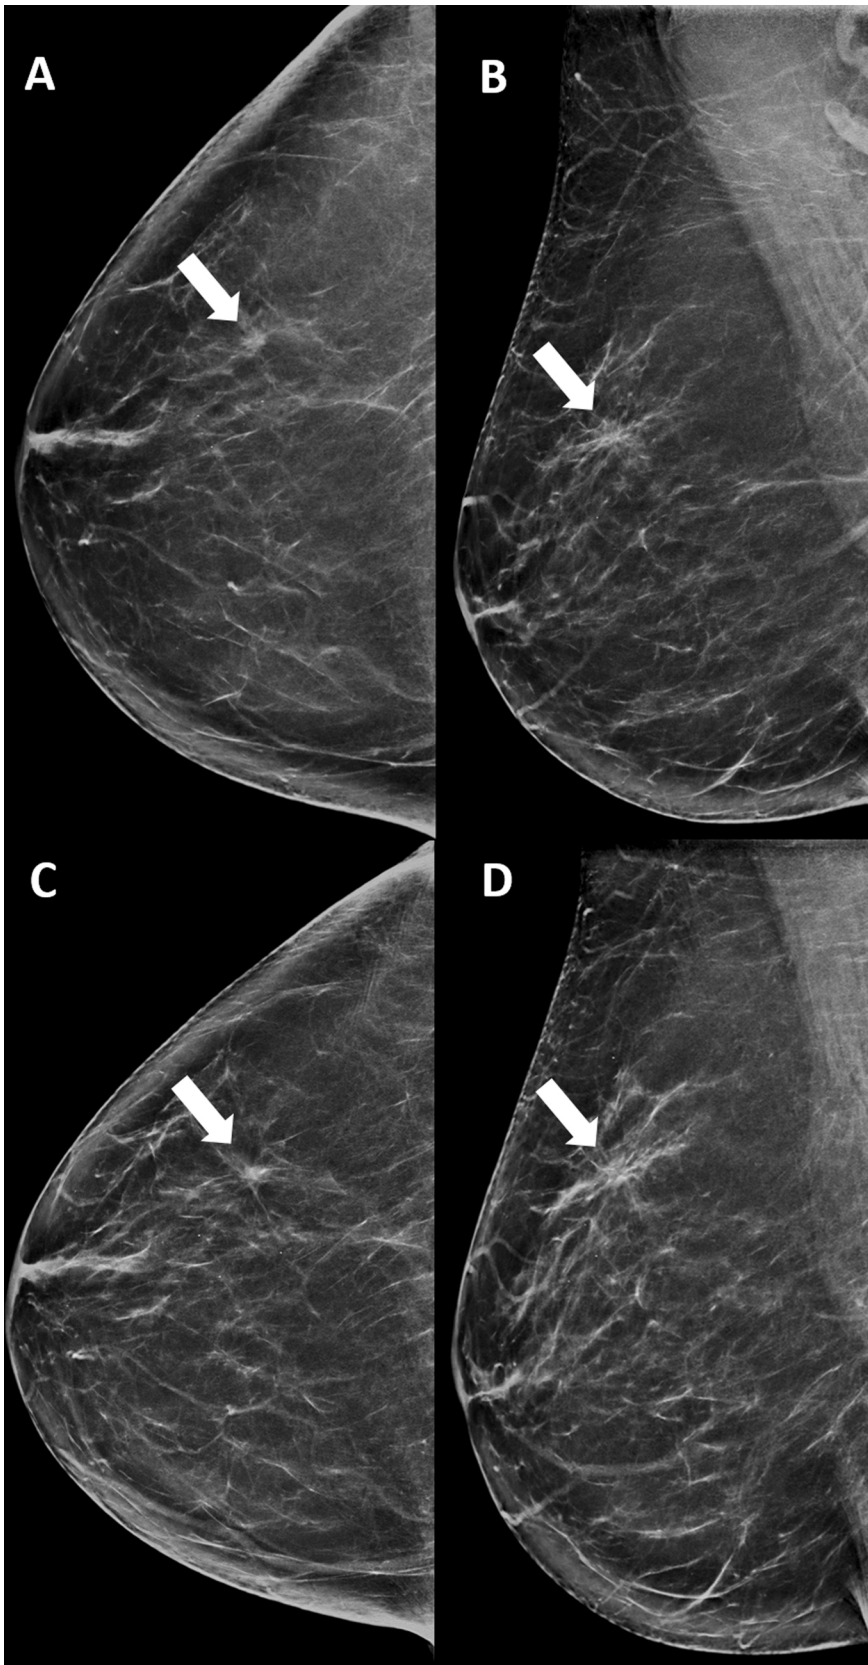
Patient example of a 24-month delay due to erroneous BI-RADS classification by the clinical radiologist. Two-view screening mammograms (A and C, cranio-caudal (CC) view, and B and D, medio-lateral oblique (MLO) view) of the right breast at recall in 2015 show a lesion in the upper lateral quadrant of the right breast. Images A and B show the lesion in 2015 (white arrows), classified as BI-RADS 4 by the screening radiologists. Digital breast tomosynthesis and ultrasound were performed, and the lesion was classified as BI-RADS 2 (benign lesion). No biopsy was performed. At repeated recall in 2017 for the same lesion (again characterized as BI-RADS 4 by the screening radiologists), increased density of the lesion was seen, with an increase in size (images C and D). Targeted ultrasound showed a spiculated, irregular and hypoechogenic lesion, which was classified as BI-RADS 5. Ultrasound guided true-cut biopsy was performed which revealed an invasive ductal carcinoma. There were no axillary metastases (TNM: T1bN0). The patient was treated with breast conserving surgery and adjuvant radiotherapy.
